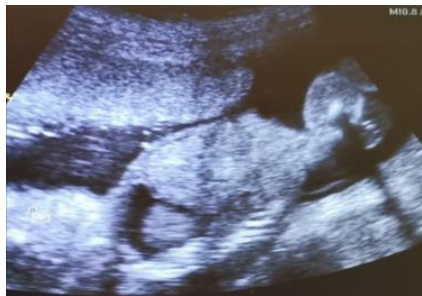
Obstetrical ultrasonography indicates bilateral pleural effusion at 18-week 3-day POA
